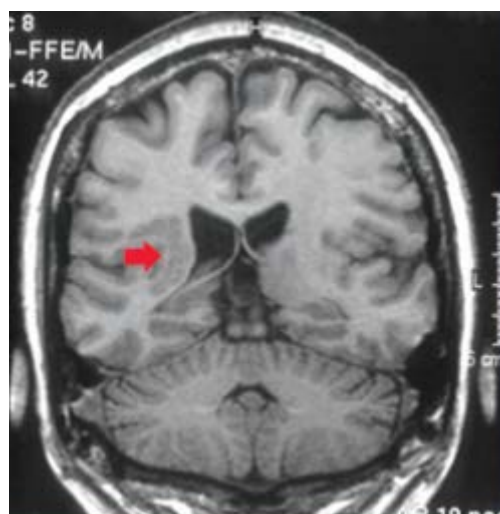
MRI scan shows multiple gray matter heterotopia [10].
